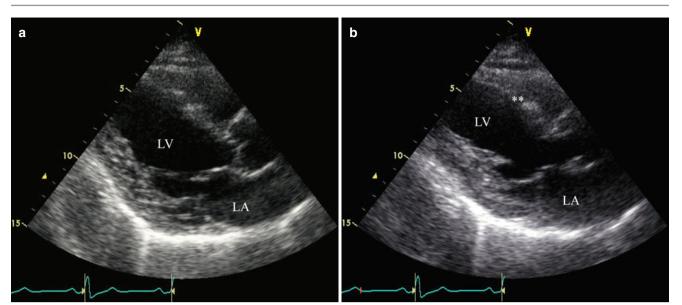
(a) Parasternal long-axis view in a case of anteroapical myocardial infarction during diastole. (b) During systole, the anteroseptal wall (*asterisks*) of the left ventricle (*LV*) is dyskinetic and bulges outward instead of contracting. *LA* left atrium
